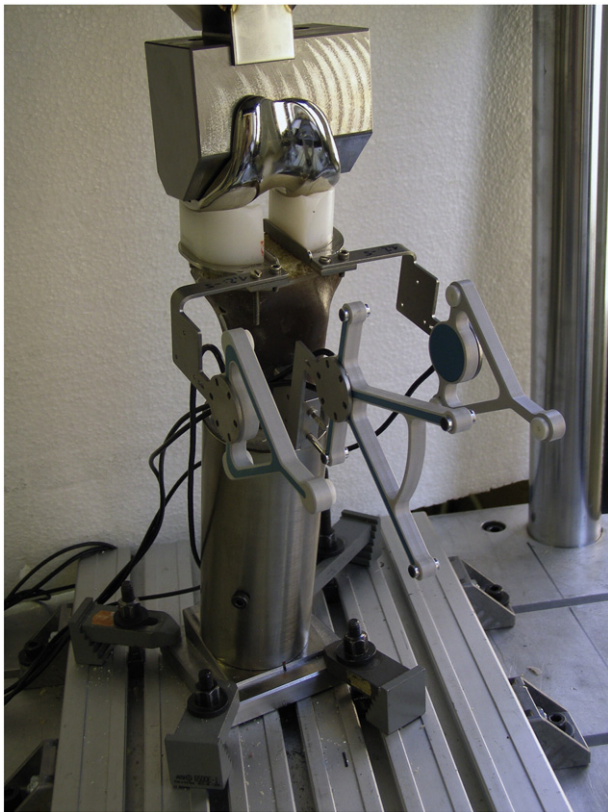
Experimental set-up: sinusoidal load application with a four-column dynamic test machine (Dyna-Mess, Stolberg, Germany). A special control device was used to distribute axial force over a conventional femoral component (e.motion® size F7, Aesculap AG, Tuttlingen, Germany) and the fitted inlays. To measure the relative motion between the JS and the bone, an ultrasound-based 3D motion analysis system (CMS20BI, Zebris, Isny, Germany) was used.
